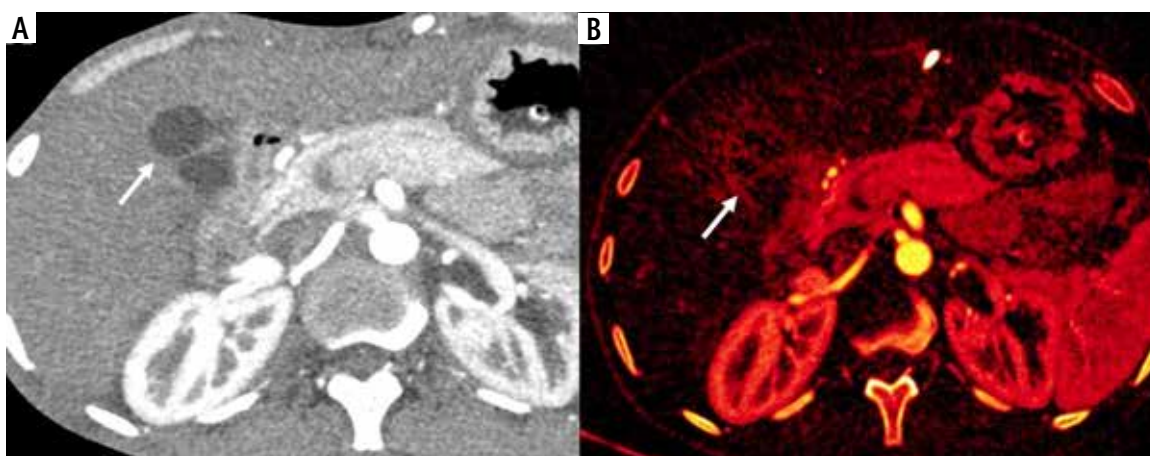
Dual energy CT in wall-thickening type of gallbladder cancer (GBC). A) Axial contrast enhanced CT (CECT) image in arterial phase shows circumferential thickening of the body and fundus of the GB (arrow). B) Axial iodine overlay dual-energy CT image shows iodine uptake in the thickened areas favoring the diagnosis of malignancy (arrow)
